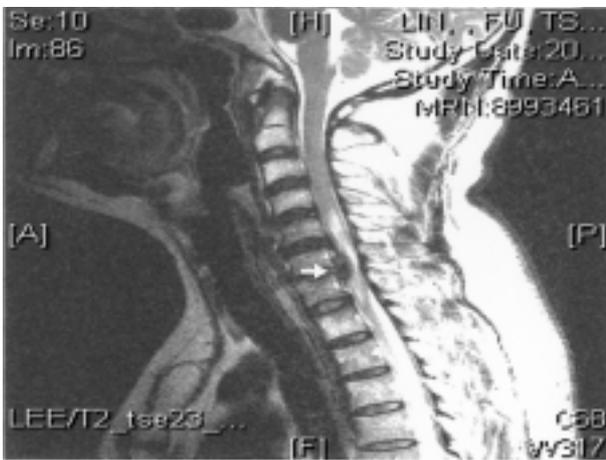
Magnetic resonance imaging demonstrates disc protrusion at C6-C7 (arrow) with spinal cord compression.
